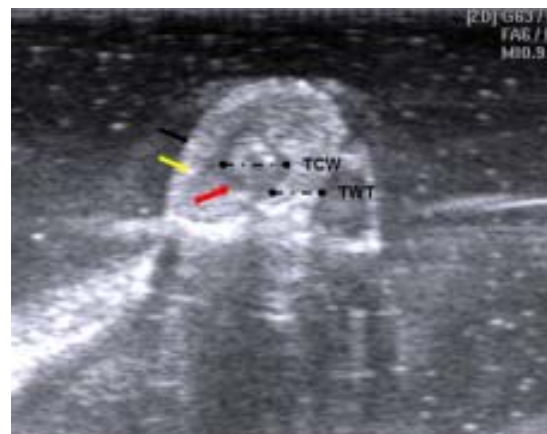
Transverse ultrasound scan of the teat in lactating Jenny demonstrating the multi-layered structure of the teat including the hyperechoic skin (black arrow), hypoechoic muscle layer (yellow arrow) and hyperechoic mucosa (red arrow). The teat canal width (TCW) and teat wall thickness (TWT) are also presented.
